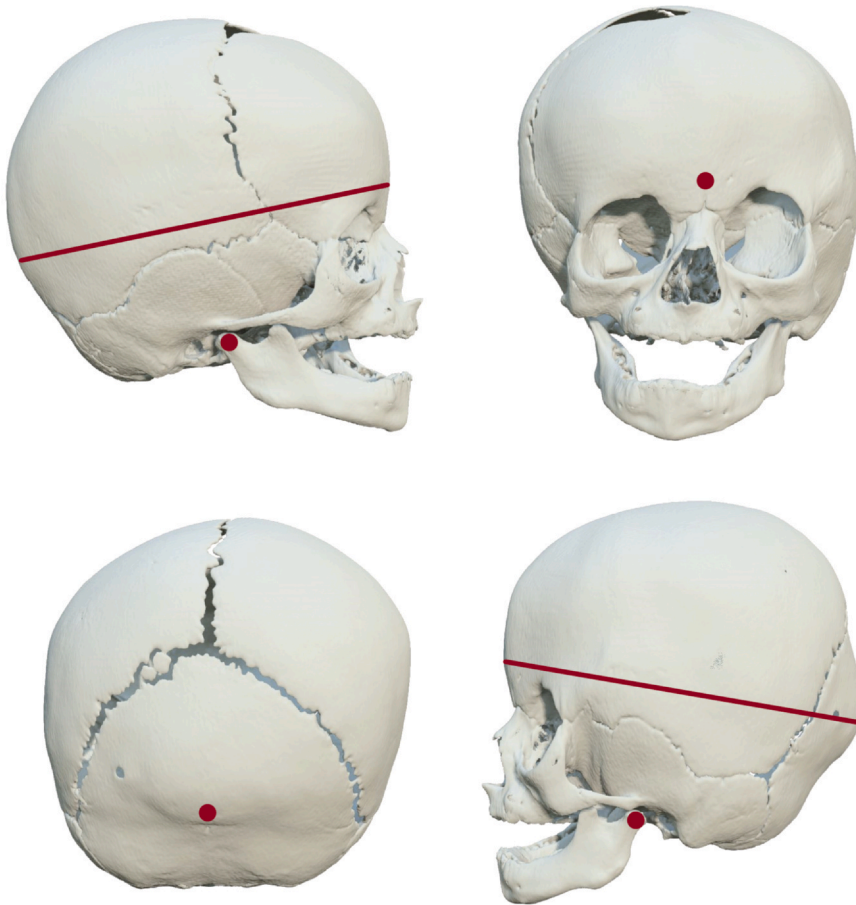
Calculated head circumference (red lines) based on CT scan measurements of head length (glabella to opisthocranium) and mandibular width (most lateral points of the mandible).
